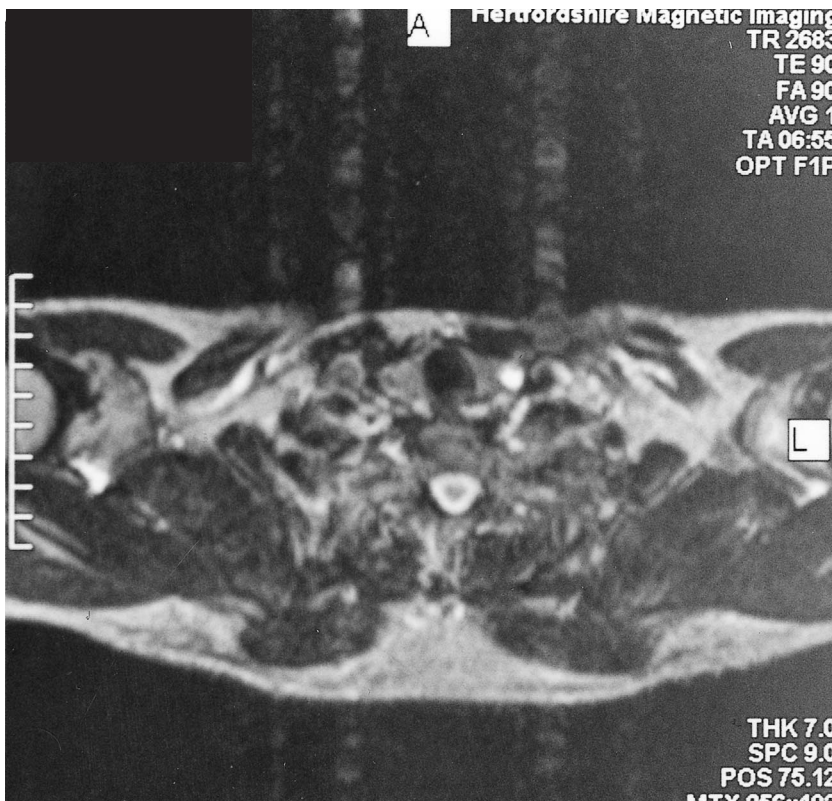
Magnetic resonance imaging scan of the brachial plexus. A 1.5 cm high signal lesion is situated in the lateral part of the left thyroid lobe.
